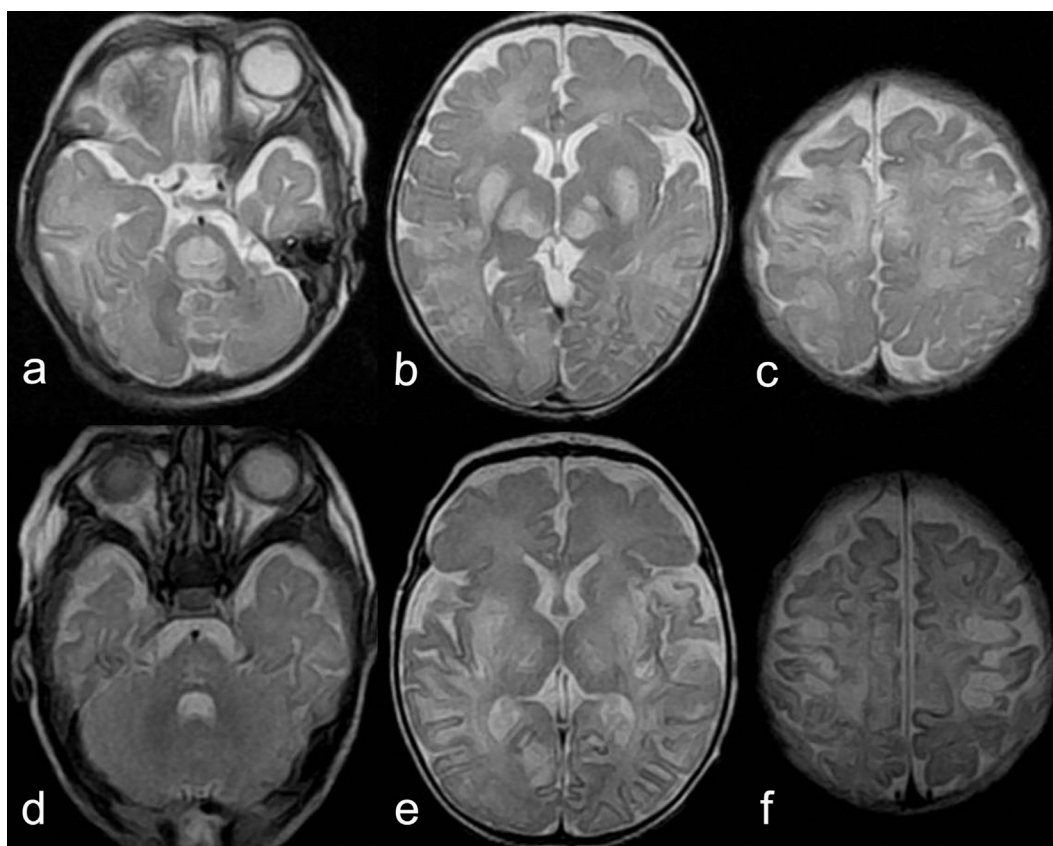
Axial T2-weighted MR images before (a–c) and 2 months after (d–f) treatment with thiamin and biotin. Increased signal intensity in the pons (a). Abnormal high signal and swelling of the putamina, globus pallidi and thalami (b). Cortical and sub-cortical high signal areas in the bilaterally cerebral hemispheres (c). Follow-up MR imaging after treatment (d–f) shows regression of the increased signal in the pons (d), globus pallidi, putamina and thalami (e). Pathologic changes have evolved cystic encephalomalacia in the cerebral hemispheres (f).
